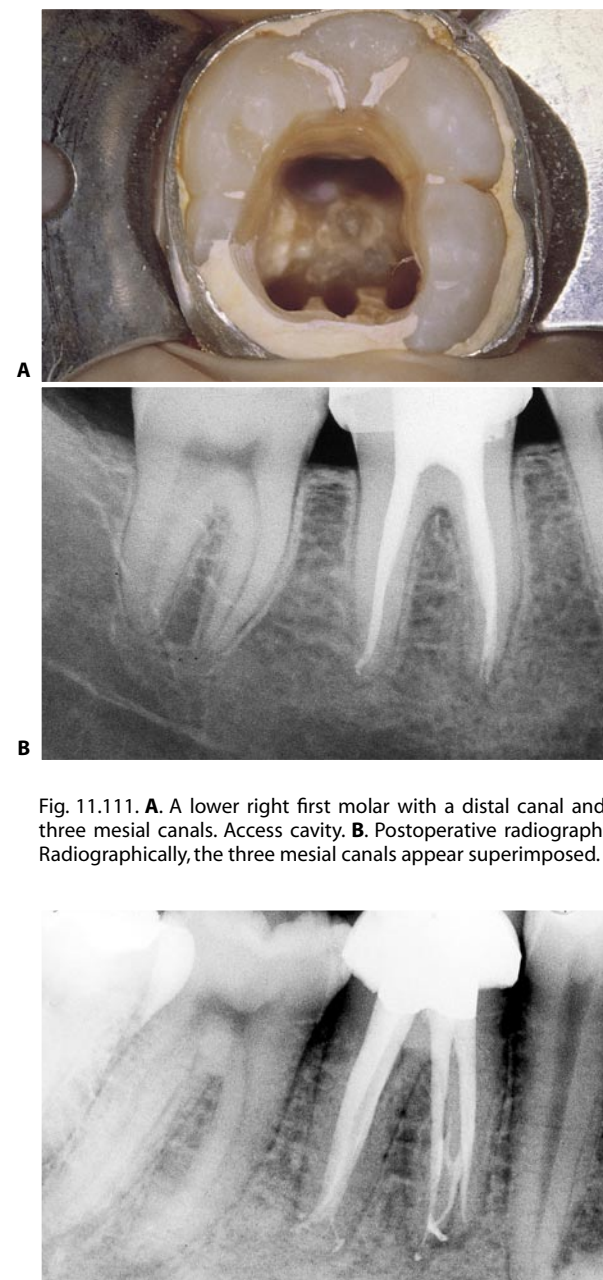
A. A lower right first molar with a distal canal and three mesial canals. Access cavity. B. Postoperative radiograph. Radiographically, the three mesial canals appear superimposed.
